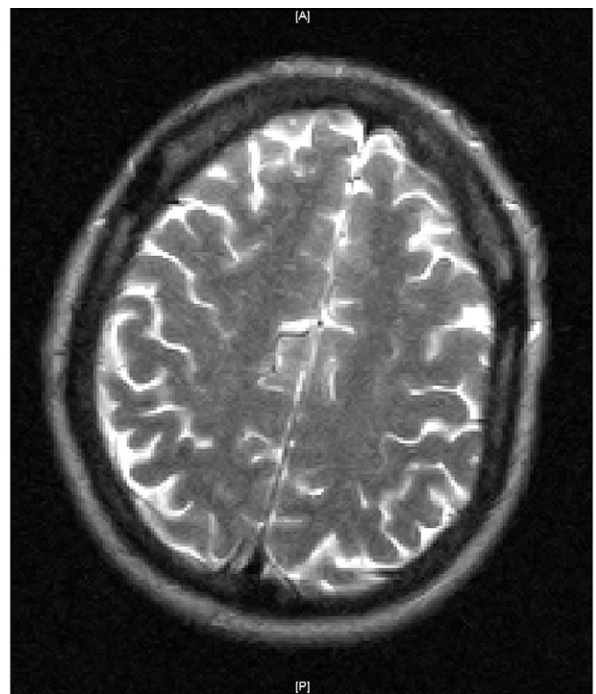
Preoperative MRI scan shows area near the intended lead entry site.
